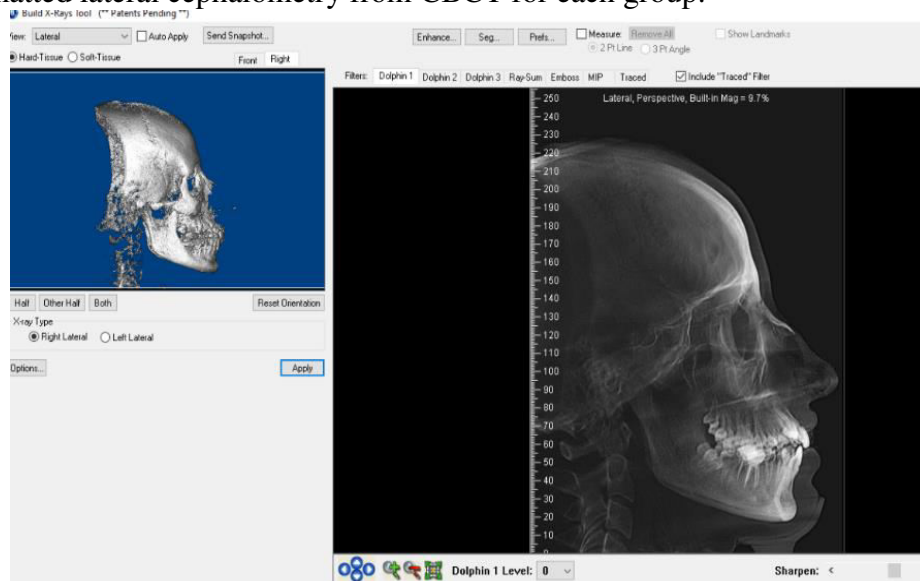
showing lateral cephalometry from CBCT
